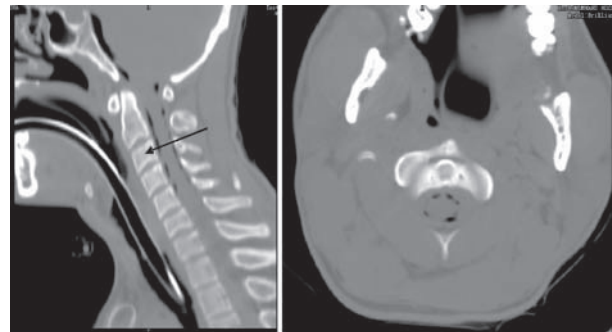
Multiplanar reformatted spinal CT images demonstrating traumatic cervical intra-dural air (Arrow).
